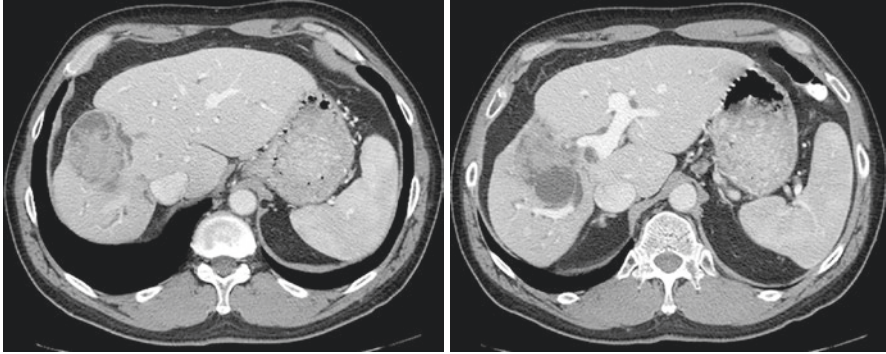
Computed tomography images of intraductal papillary neoplasm of the bile duct that transformed to invasive intrahepatic cholangiocarcinoma
